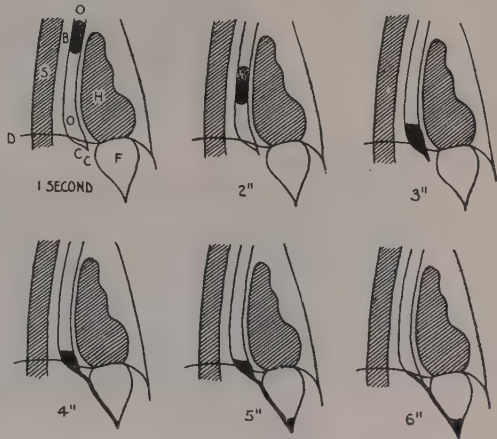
Appearance of lower end of Esophagus and Cardiac Sphincter, at one to six seconds after swallowing; observed under X-rays. (HURST.)
